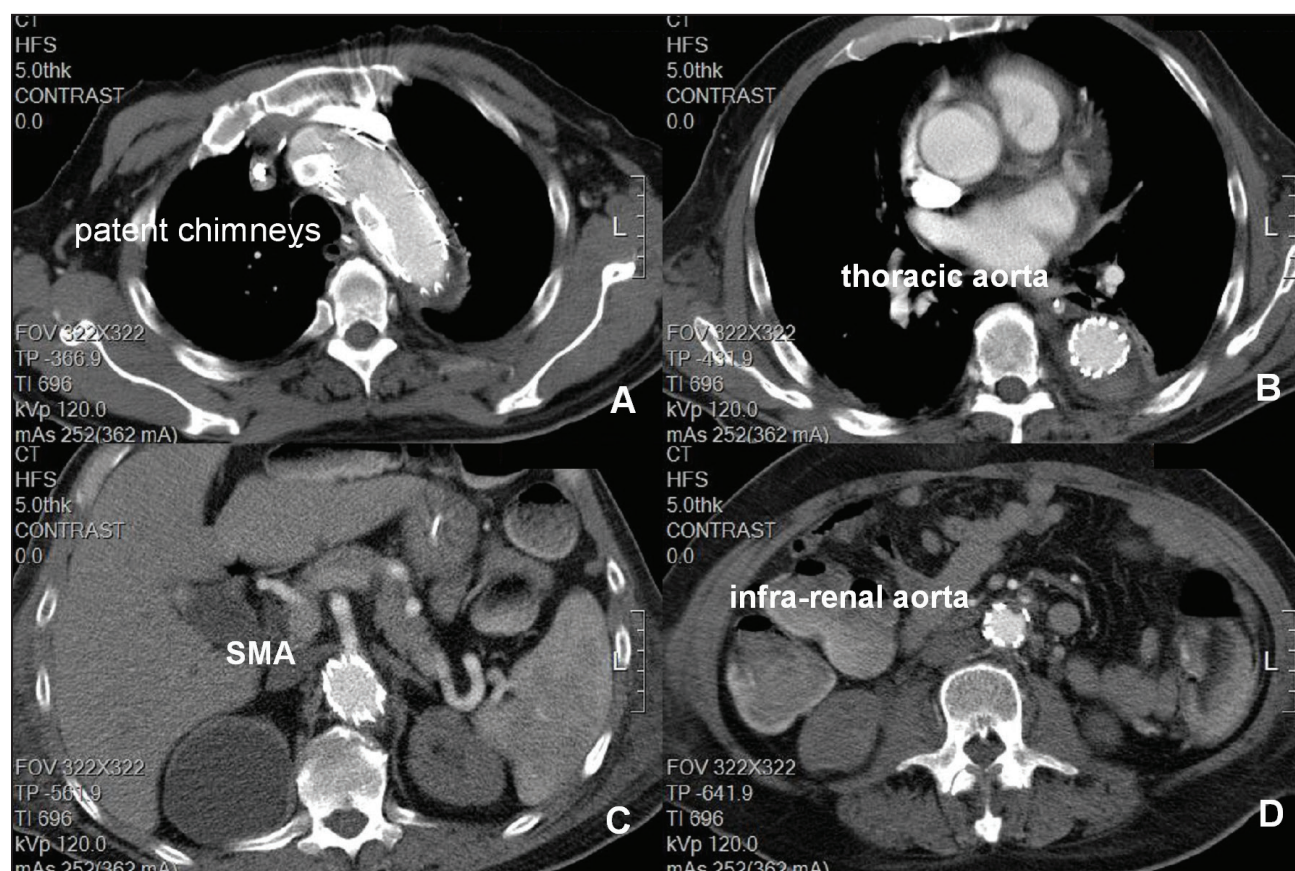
A follow-up CT was performed 1 month later. The chimney and periscope grafts were patent (A). The true lumen fully expanded all the way down (B–D).
